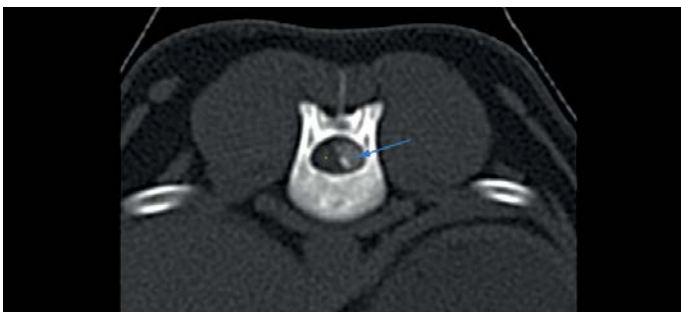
Reconstruction of a computed tomography image in bone algorithm showing an extruded mineralized, hyperattenuating disc (arrow), causing a moderate right lateral disc compression of the adjacent spinal cord.
